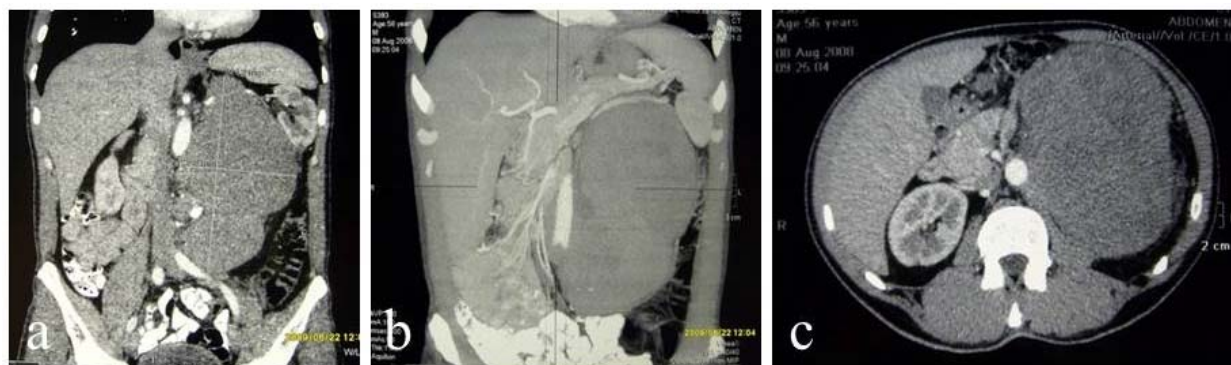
Computed tomography shows a solid nonhomogenous tumor mass in the retroperitoneum (a – frontal section), relationship with the surrounding vascular structures (b – frontal section), and the signs of aortic wall infiltration (c – axial section).
